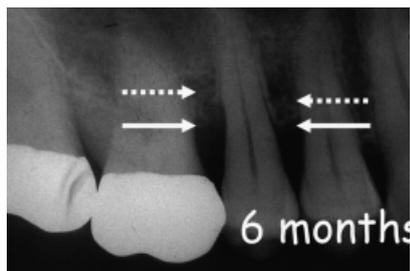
X-ray at 6-month follow-up. Note the amount radiographic bone fill.
